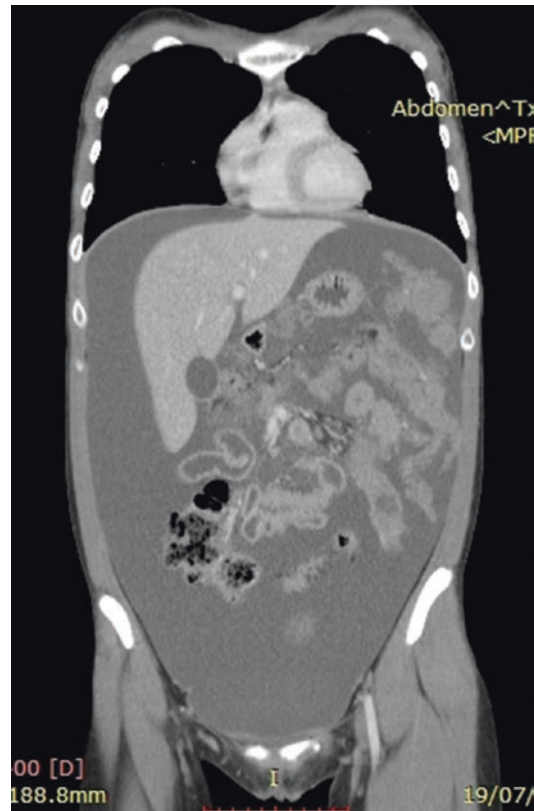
Abdominal-pelvic CT scan showing the typical appearance of “wet” DMPM. The radiological picture is characterized by abundant ascites in all the abdominal-pelvic quadrants, with relatively limited peritoneal solid nodules
